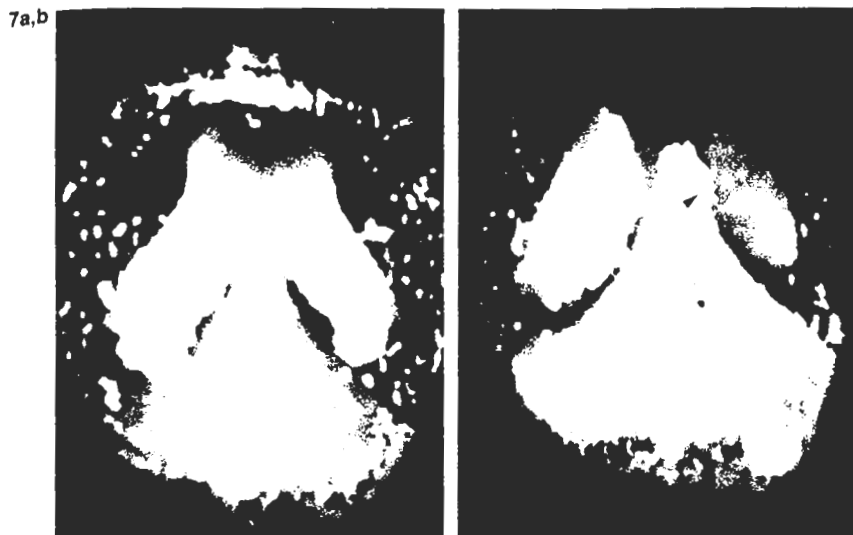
3D noncontrast CT scans show Dandy-Walker malformation in a 1-day-old girl. Superior (a) and postero-superior oblique (b) views demonstrate the relationship of the fourth ventricular cyst to the splayed atria and to the inferior surface of the falx that notches (arrowhead, b) the top of the cyst.
